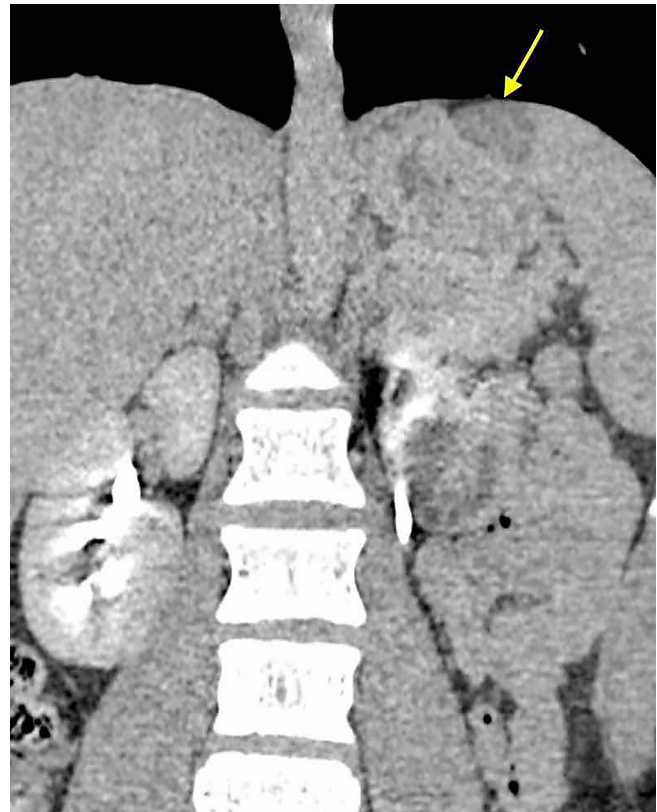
CT Scan showing apical splenic infarction (arrow), 6 years after ASD closure.
